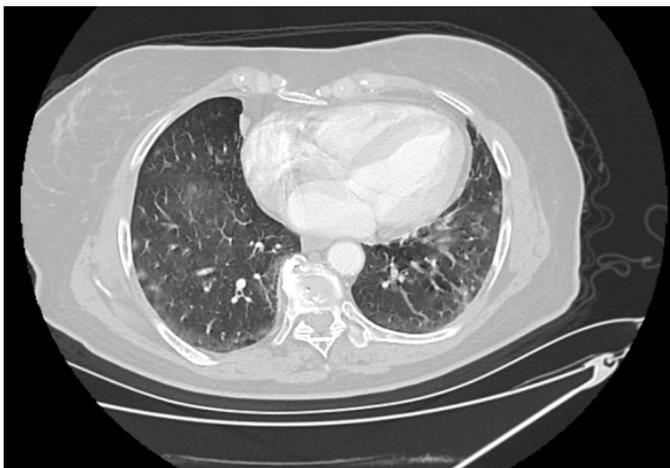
Lung computed tomography showed diffused consolidations and ground-glass opacities in both lungs, and bilateral pleural effusion
